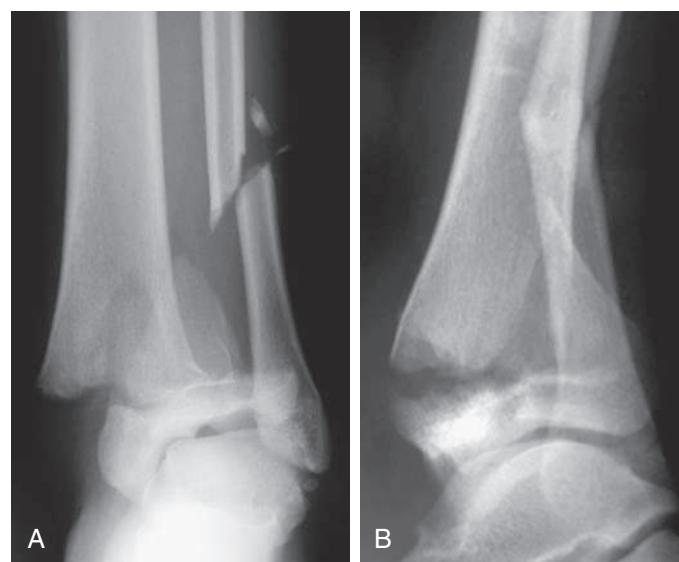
The triplane fracture is a transitional fracture: anteroposterior (A) and lateral (B) radiographs. (From Dormans JP. *Pediatric Orthopedics: Introduction to Trauma*. Philadelphia: Mosby; 2005:38.)
